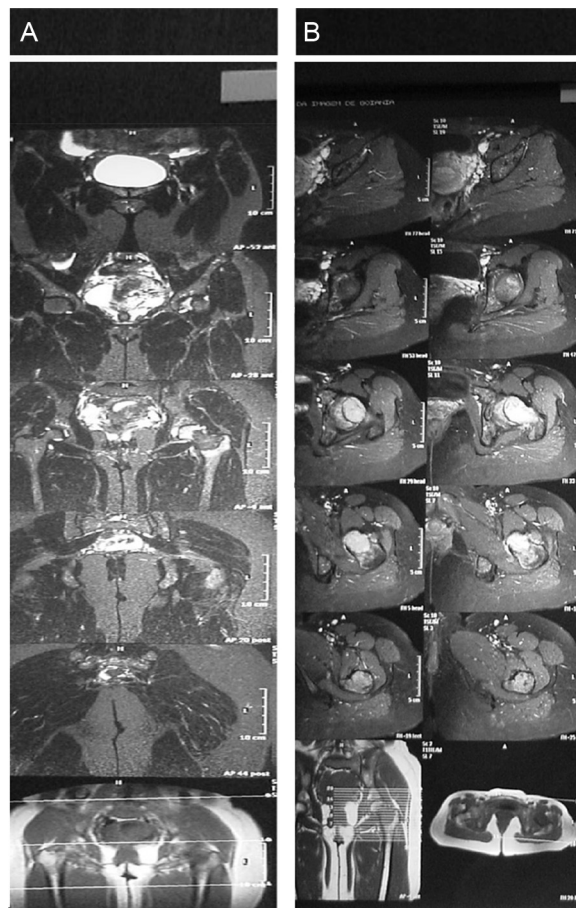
Magnetic resonance imaging of the pelvis, coronal in T2 (A), and axial plane with contrast in T2 (B) showing lesion in the left femoral neck.
